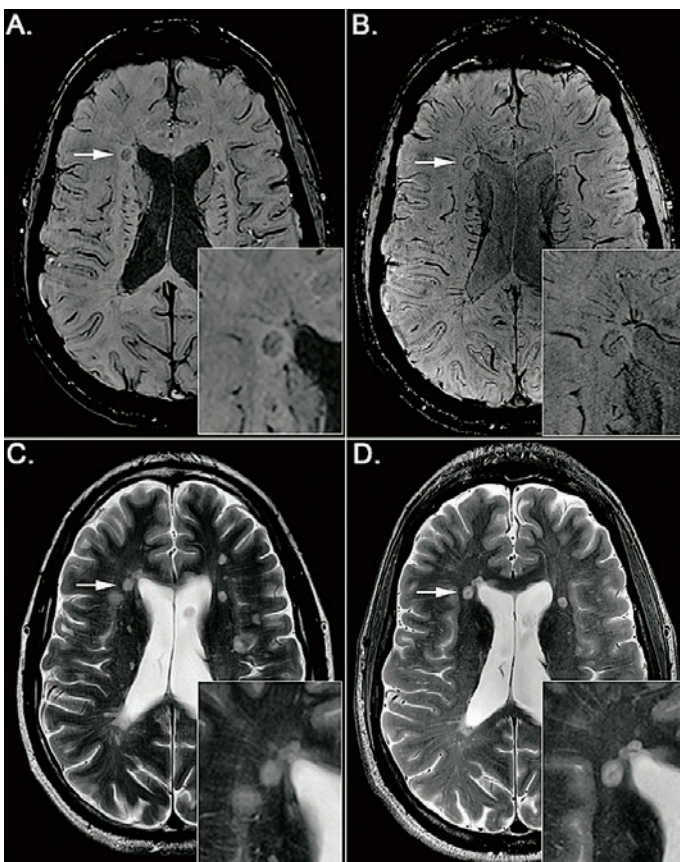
3T (A and C) and 7T (B and D) MRI of a patient suffering from MS
